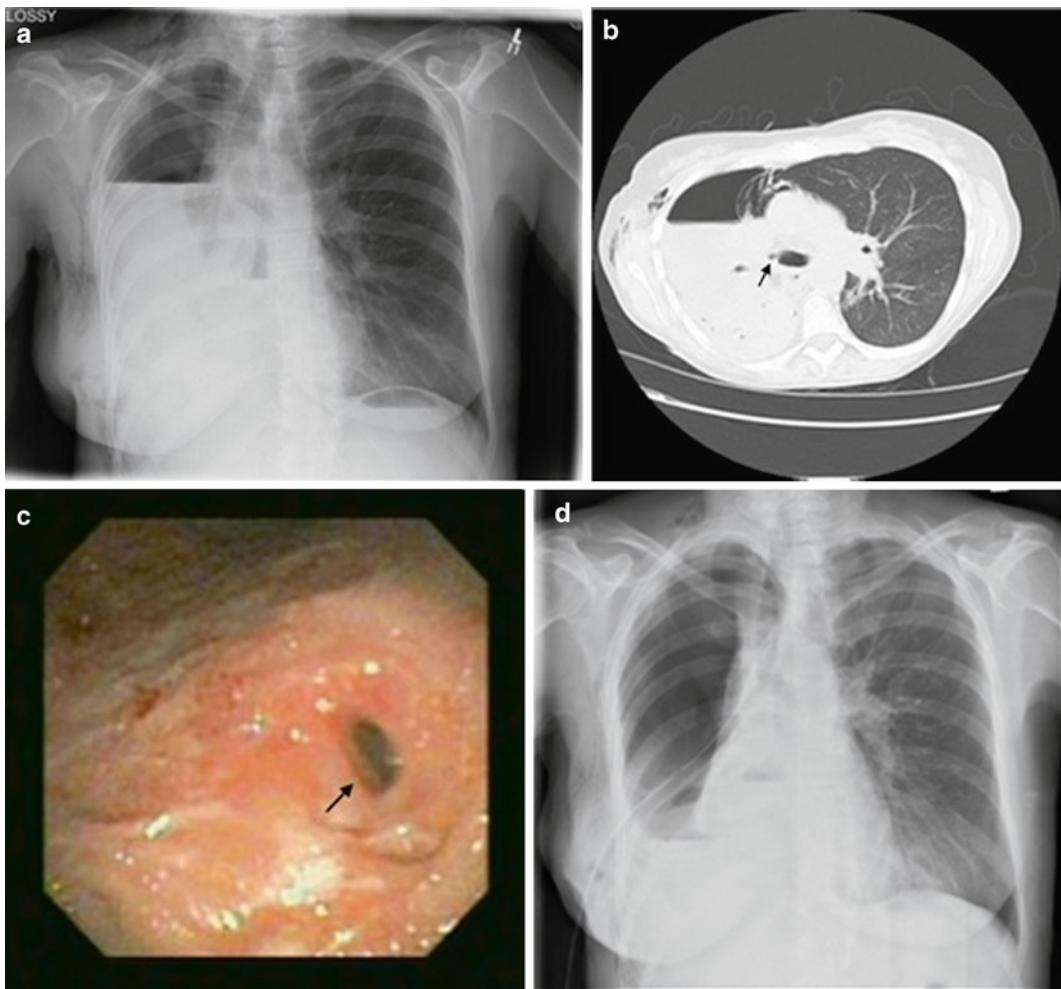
Diagnosis and initial management of postpneumonectomy broncho-pleural fistula (BPF). (a) A chest X-ray 7 days after right pneumonectomy with the fluid level in the right chest almost reaching the carina. At this time the patient presented with a new onset of coughing. (b) A CT scan showed air in the mediastinum close to the bronchial stump (arrow) and subcutaneous emphysema (arrow), suspicious for a BPF. (c) A bronchoscopy confirmed the diagnosis of a BPF (arrow). (d) As initial treatment, a chest tube was inserted to drain the chest cavity and protect the left lung.
